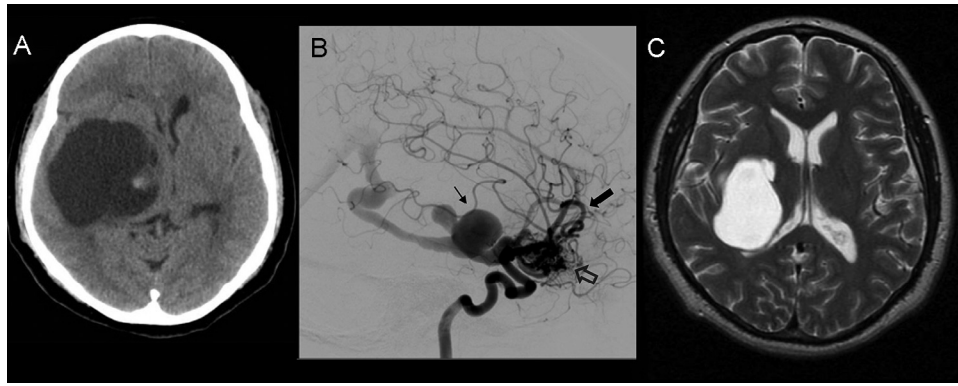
(A) Noncontrast CT: large hypodense space occupying lesion with CSF-like content. 13-mm midline shift. (B) DSA. Lateral view. Large plexiform AVM with main afferent from anterior cerebral artery (black arrow) and secondary afferent from fronto-basal branches on the MCA. Nidus volume smaller than 6 cm (empty arrow). Voluminous venous varices (small arrow) and drainage into a dilated vein of Galen. (C) MRI T2-WI. Follow-up before surgery. Cyst volume reduction and resolution of the midline shift after the endovascular embolization. Abbreviations: AVM, arteriovenous malformation; CSF, cerebrospinal fluid; CT, computed tomography; DSA, digital subtraction angiography; MCA, middle cerebral artery; MRI, magnetic resonance imaging.
